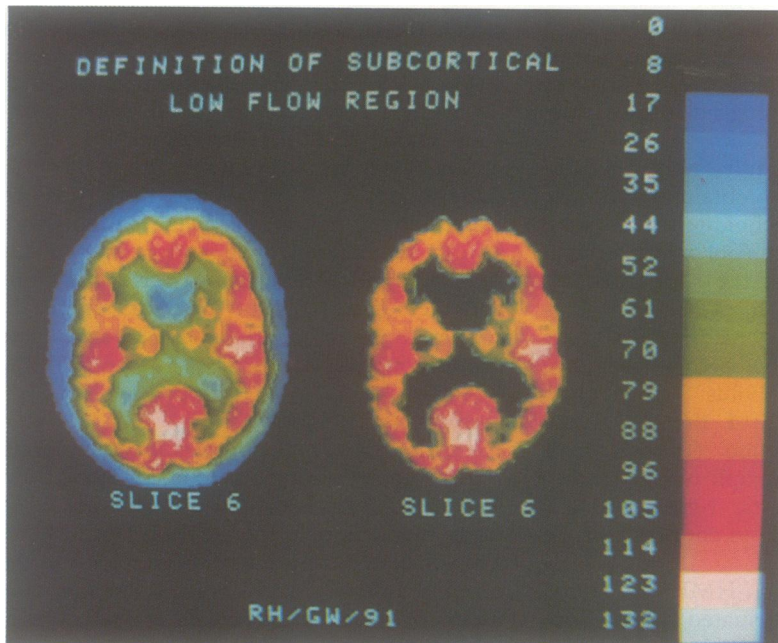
SPECT with [^{99m}Tc]-d,l-HMPAO (slice 6) in a 51 year old healthy male. The left hemisphere is shown to the left. The colour scale indicates relative regional cerebral blood flow (F(%)) values (from 0 to 140%) calculated from corrected relative countrates normalised to the cerebellum. The peak pixel value of this slice was 136% and the low flow threshold 67%. As shown to the right this threshold defined a subcortical low flow region (black), including the ventricles and periventricular tissue, and a surrounding cortical high flow region. The relative area and the mean rCBF of each region was calculated by the computer.
